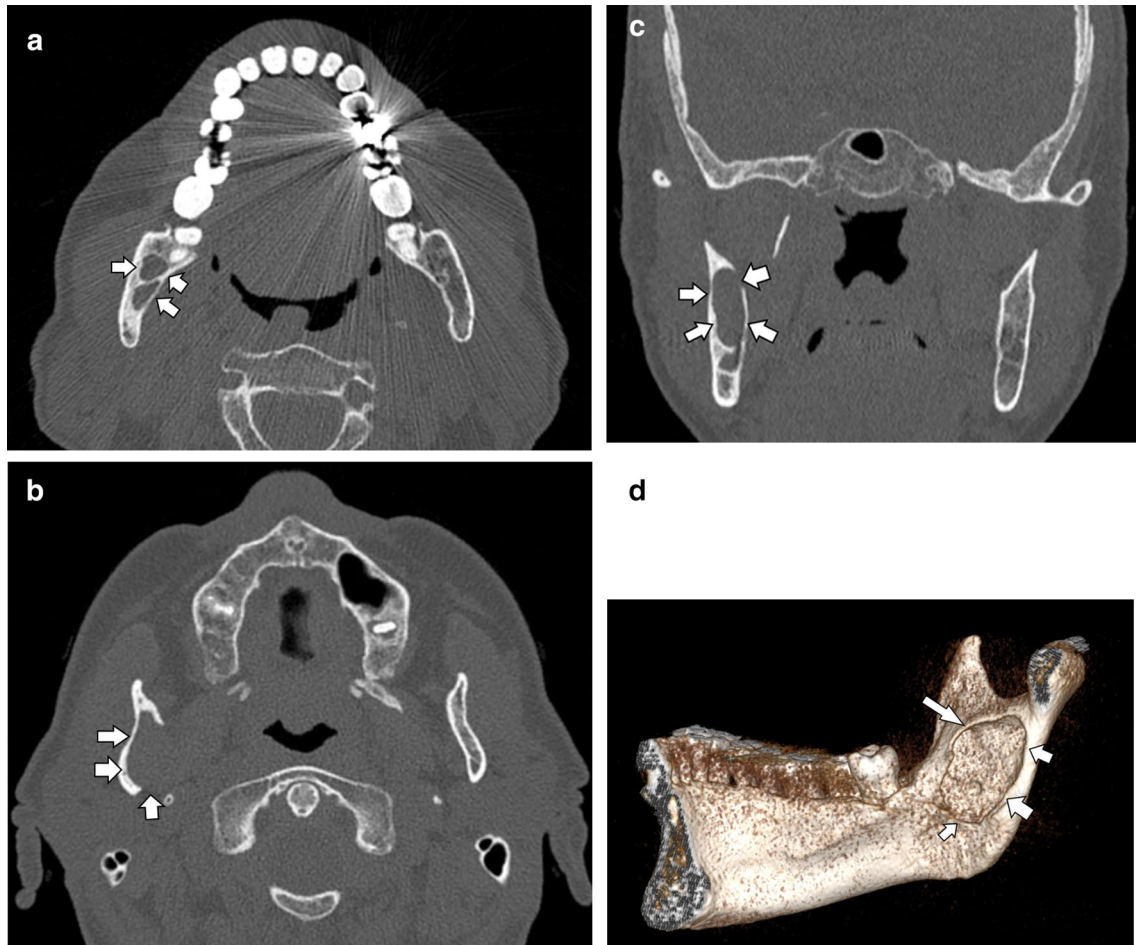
CT scans (A, B, axial; C, coronal; D 3D) performed in 2022, confirming the presence of a multilocular, expansile, well-circumscribed, osteolytic lesion located in the right ramus of mandible, with lingual cortical erosion (the arrows points the borders of the lesion)
